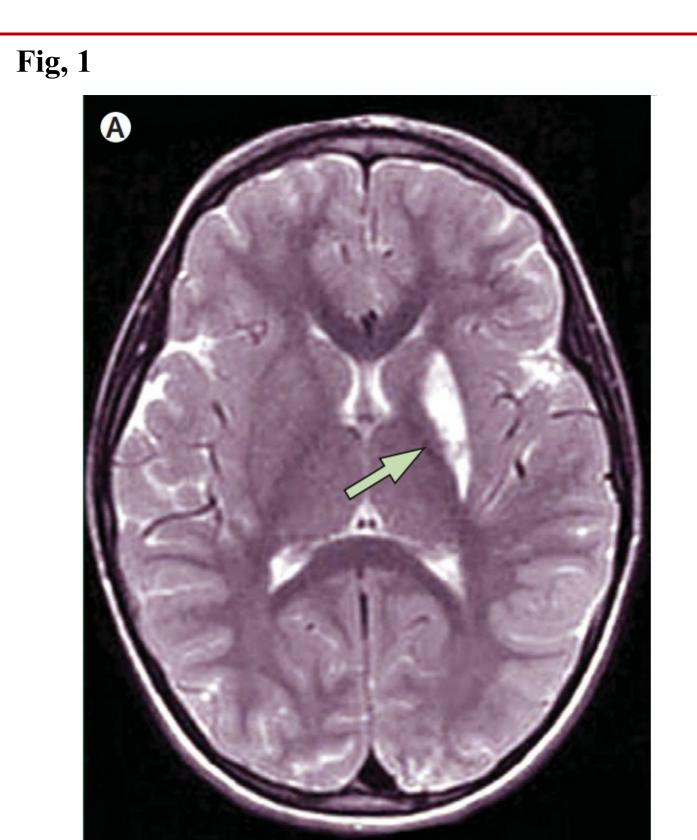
A. T2 weight MRI shows signal alterations in the left putamen (arrow)0
